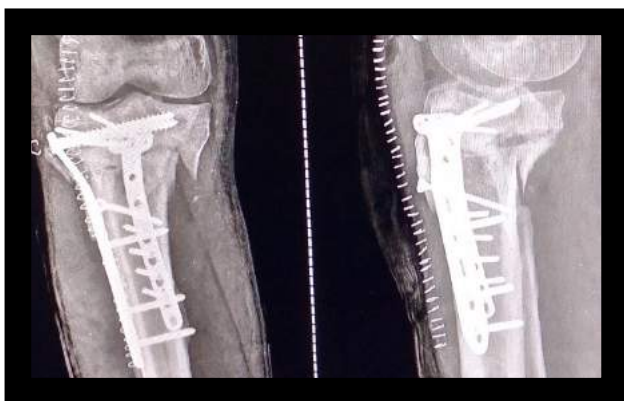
Post operative XRAY showing the congruity of the the knee joint in both angles.
